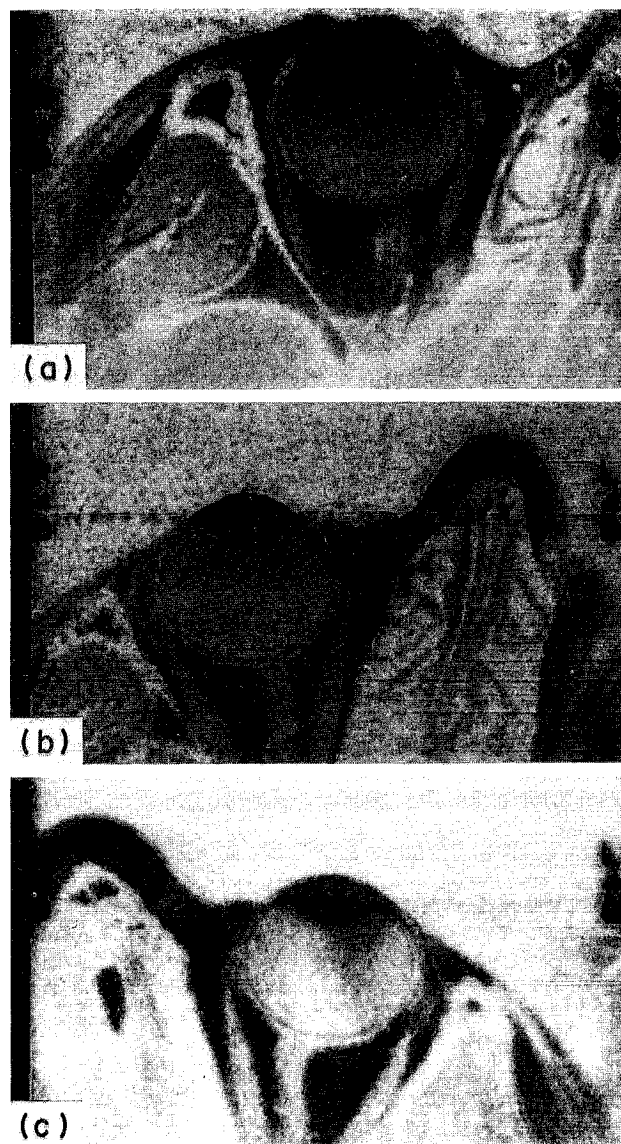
Positives of MR images. These are unenlarged, axial views. The eyes of myopic subject M1 (a), emmetropic subject E1 (b) and hyperopic subject H6 (c) are shown.
